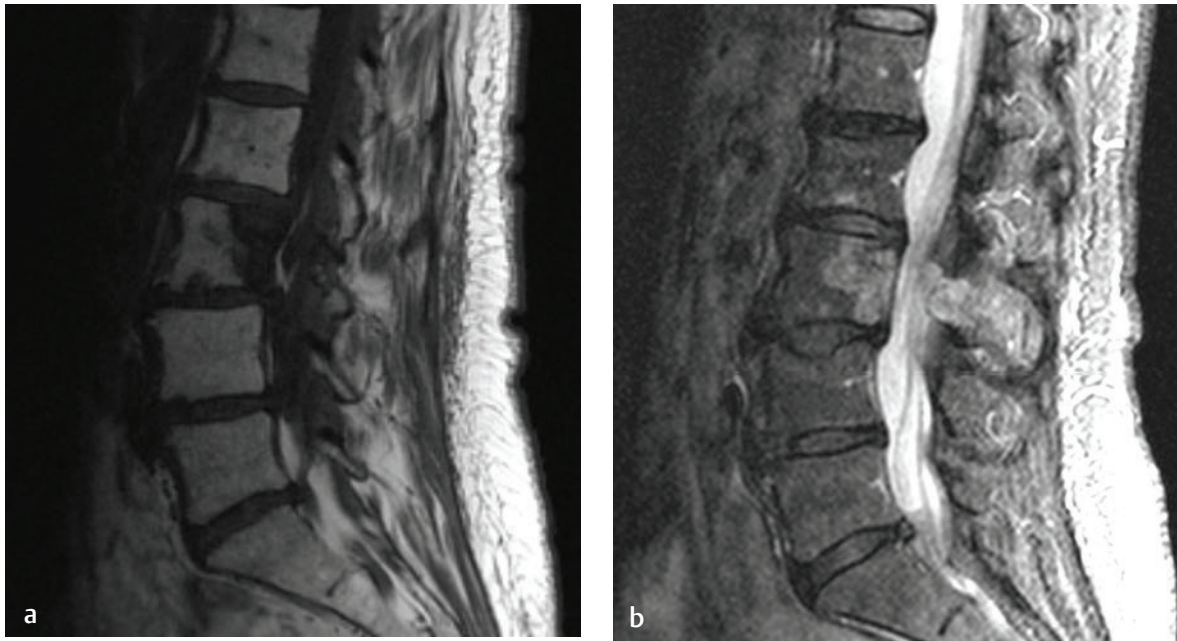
Lumbar spine metastasis from breast carcinoma. (a) A sagittal T1-weighted image shows a hypointense lesion occupying the L3 vertebral body. (b) The disease extent is more evident on this sagittal fat-suppressed T2-weighted image.
